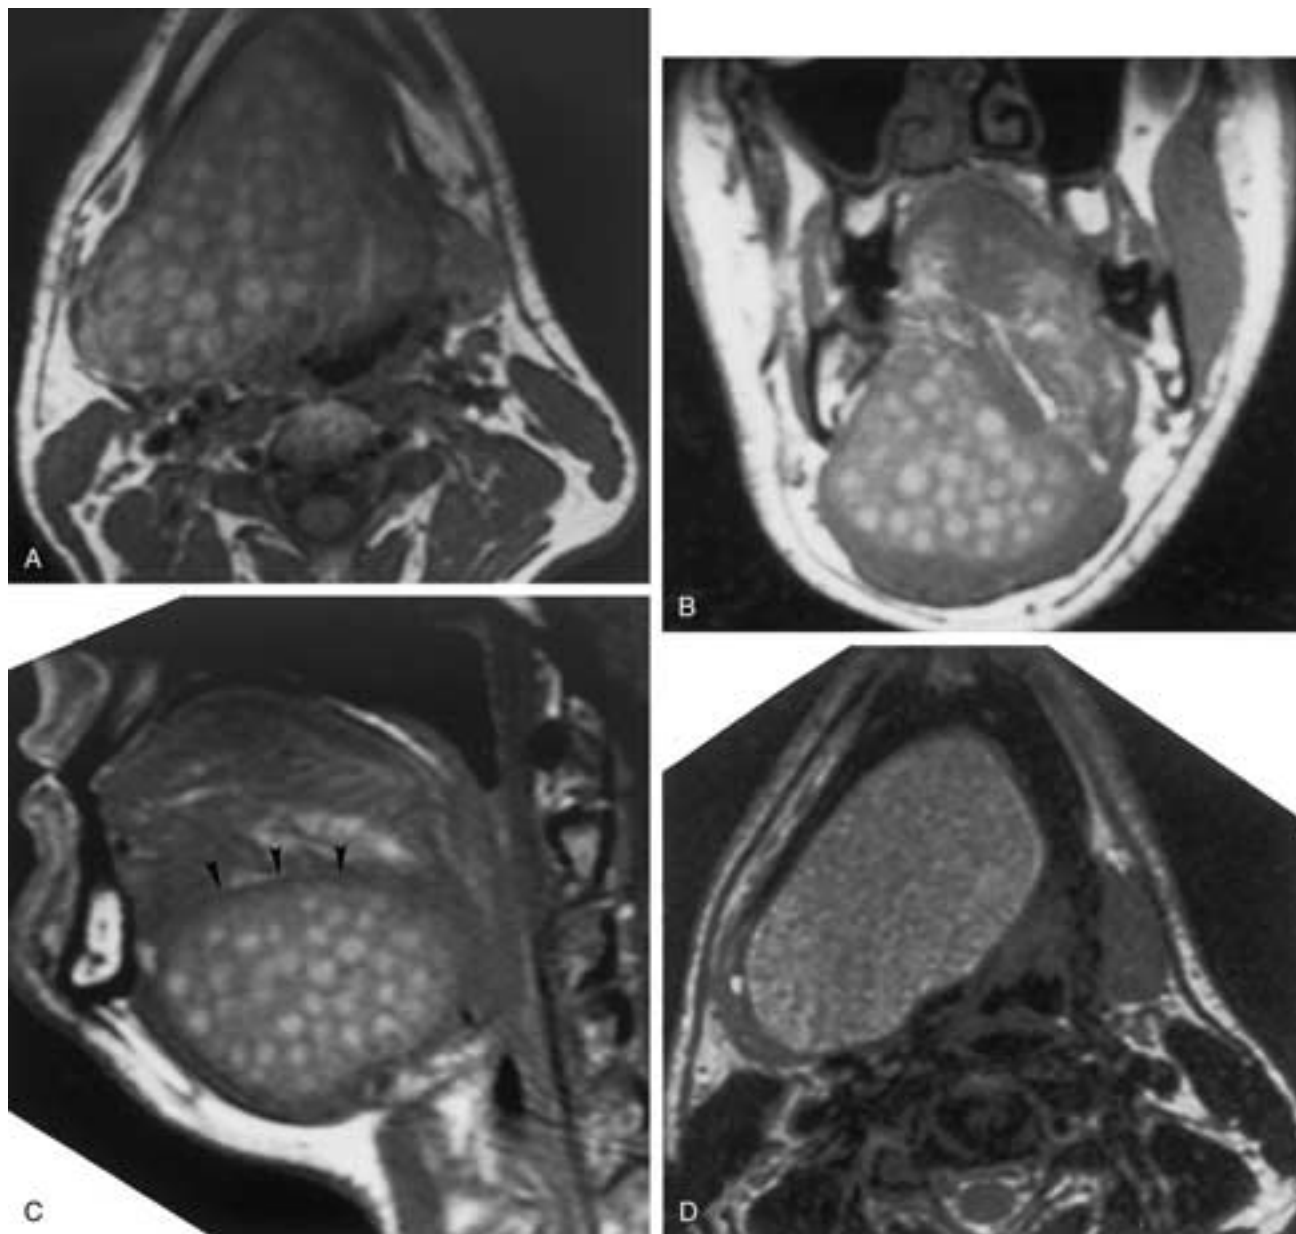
Dermoid cyst. T1-weighted MR images in the axial (A), coronal (B), and sagittal (C) planes demonstrate a large sublingual dermoid cyst characterized by multiple fat globules, which are easily identified by their high signal intensity. The relationship of this lesion to the floor of the mouth musculature is well demonstrated on the sagittal image (C), on which it lies between the fibers of the mylohyoid muscle inferiorly and those of the geniohyoid muscle (arrowheads) superiorly. Axial T2-weighted MR image (D) reveals a very heterogeneous signal to the contents of this dermoid cyst, without definition of the individual fat globules so easily visualized on the T1-weighted images. (Courtesy of Dr. Walter Rose.)
